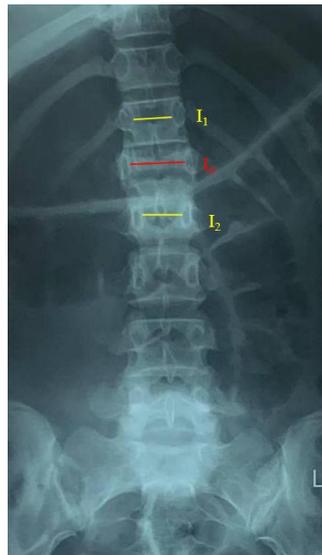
Measurement of the interpedicular distance on AP x-ray projection
